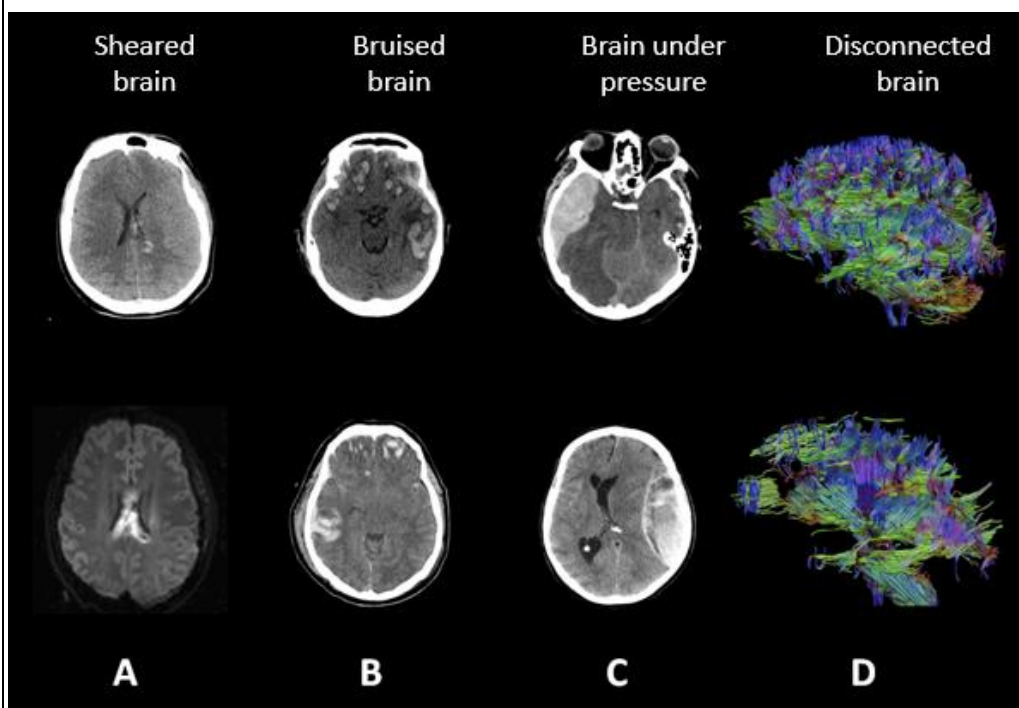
“Sheared brain”: shows the typical picture of diffuse axonal injury on CT (top panel) and diffusion weighted MR imaging (lower panel).
